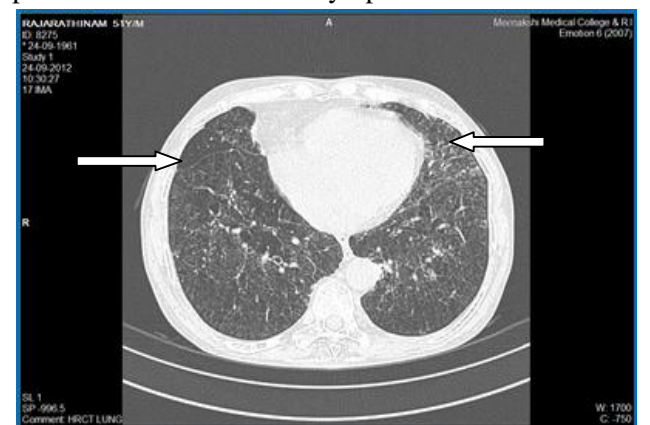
HRCT Chest showing, a. emphysematous changes and b. interstitial reticular pattern.
